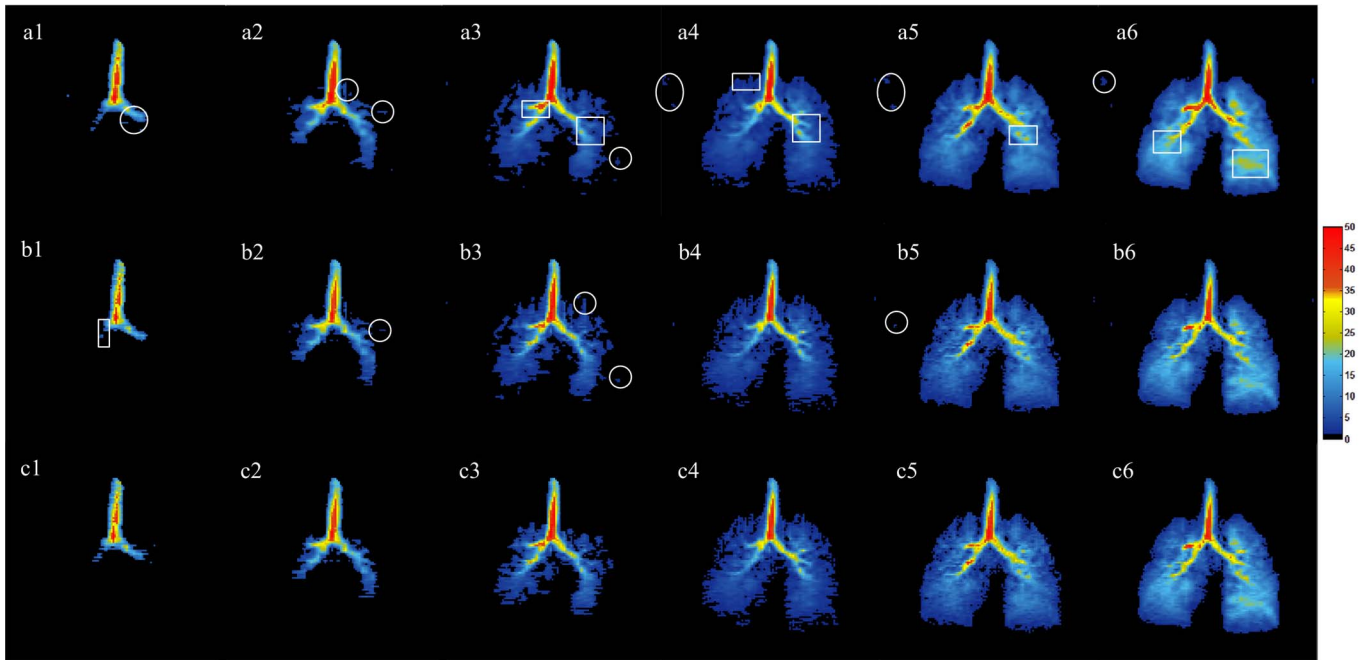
The 10<sup>th</sup>, 20<sup>th</sup>, 25<sup>th</sup>, 27<sup>th</sup>, 30<sup>th</sup>, and 32<sup>nd</sup> frames of *in vivo* HP  $^{129}\text{Xe}$  dynamic MR images through different algorithms. (a1)-(a6), (b1)-(b6), and (c1)-(c6) denote the reconstructed results obtained using the  $L + S$ ,  $L + S + G$ , and HUP algorithms, respectively.
